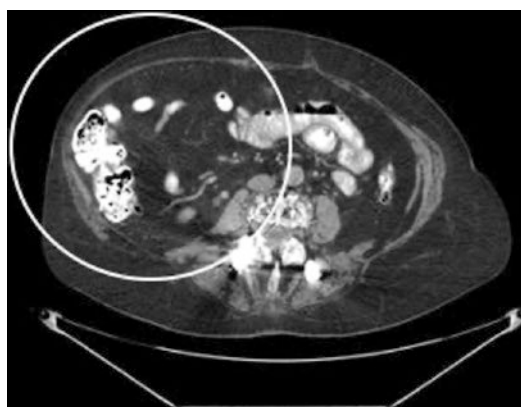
Computed tomography scan showing eventration of the right lateral abdominal wall. The musculature on the right side has thinned out compared with the left side, which is the definition of eventration and causes bulging of the right flank on physical exam
